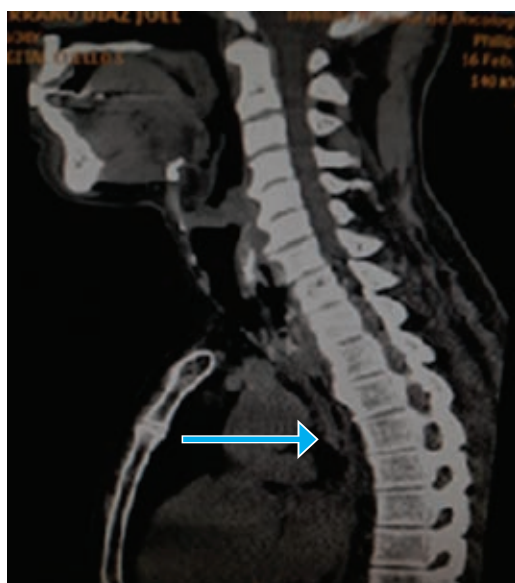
CT scan with image between the cervical esophagus and cricoid cartilage.
